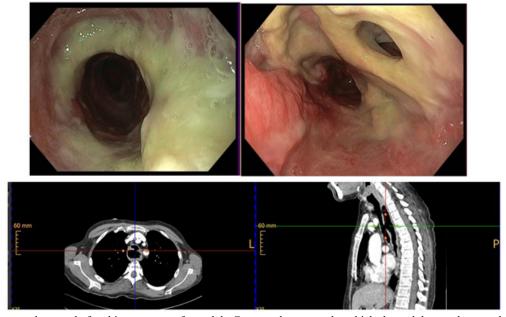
Initial upper endoscopy before biopsy was performed. b. Computed tomography which showed the esophagotracheal fistula, 3 centimeters above the carina with a diameter of 7-9 millimeters. c. Esophagotracheal fistula seen in consecutive upper endoscopy.
